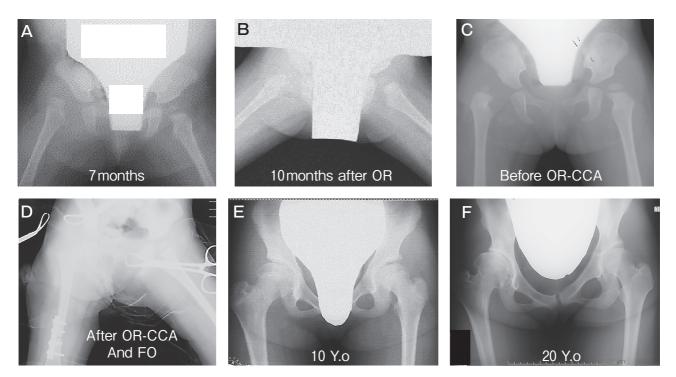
Sample case with prior OR-CCA. A, Right-side developmental dysplasia of the hip at the age of 7 months after birth; B, X-ray imaging at the age of 10 months after birth; C, X-ray imaging after walking age showing redislocation; D, X-ray imaging at the age of 27 months of distal derotation femoral osteotomy after Colonna capsular arthroplasty; E, X-ray imaging at the age of 10 years; F, X-ray imaging at the age of 20 years.
